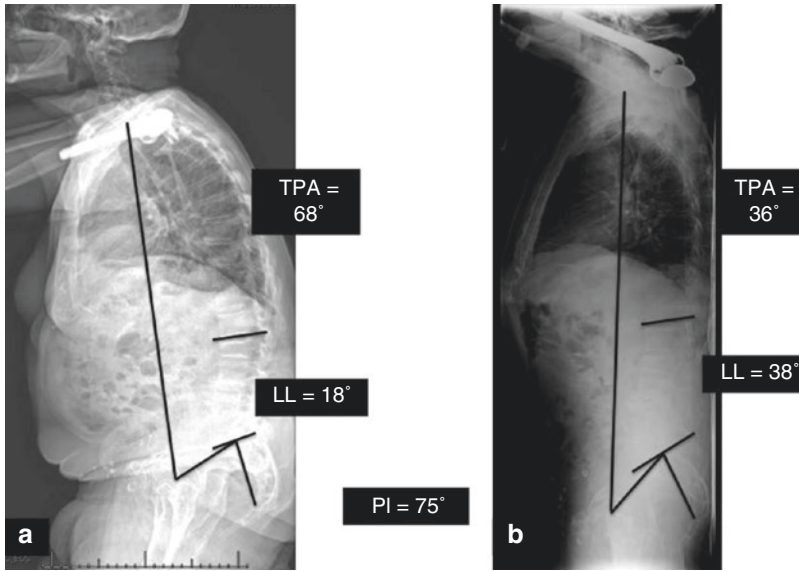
(a) Standing lateral radiograph of a 73-year-old male with adult spinal deformity. T1 pelvic angle (TPA) is 68°, lumbar lordosis (LL) is 18°, and pelvic incidence (PI) is 75° with a PI-LL mismatch of 57°. (b) Supine lateral
